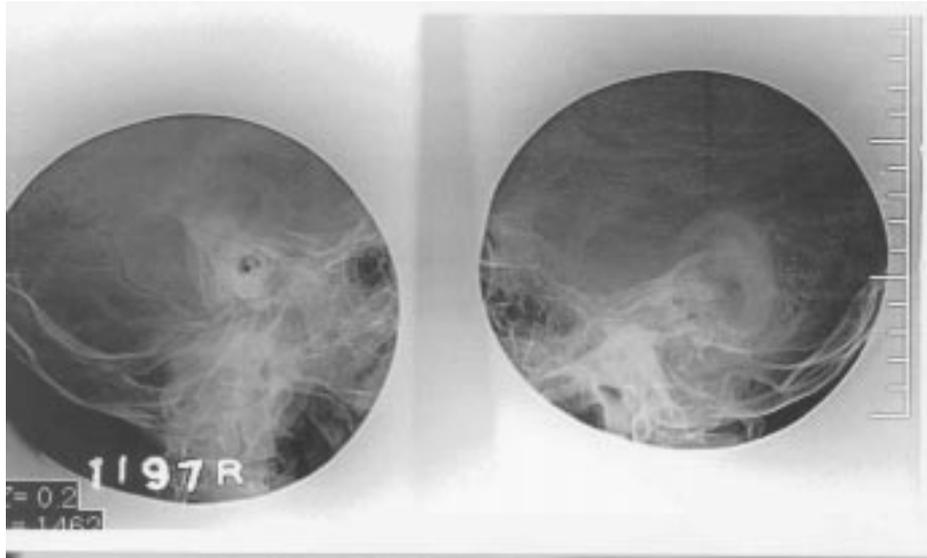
Digital X-ray of mastoid region (Law's lateral oblique view) showing bilateral absence of mastoid air cells with radio opaque densities seen more on left side suggestive of chronic mastoiditis.
